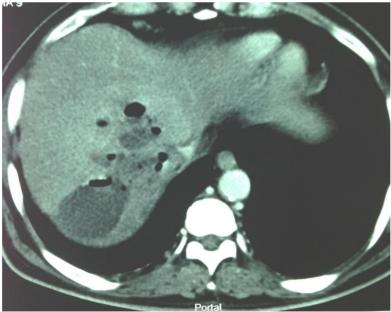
CT Scan Showing the Large Gas Producing Liver Abscess
